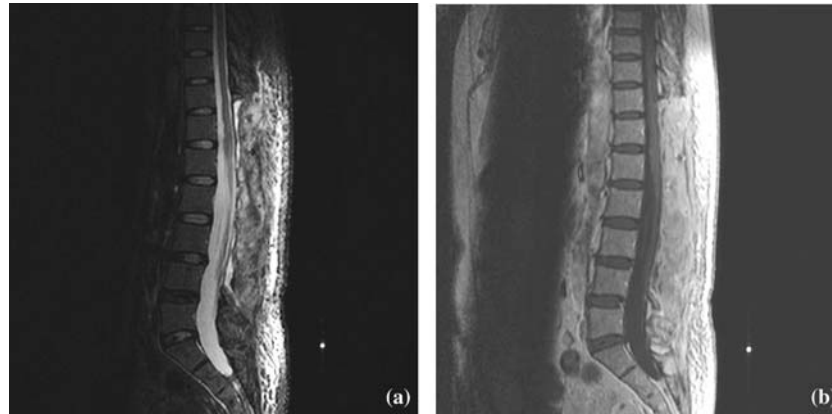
MRI 6 months after surgery. No tumor mass is seen: (a) T₂-weighted image, (b) Gadolinium-enhanced T₁-weighted image.
